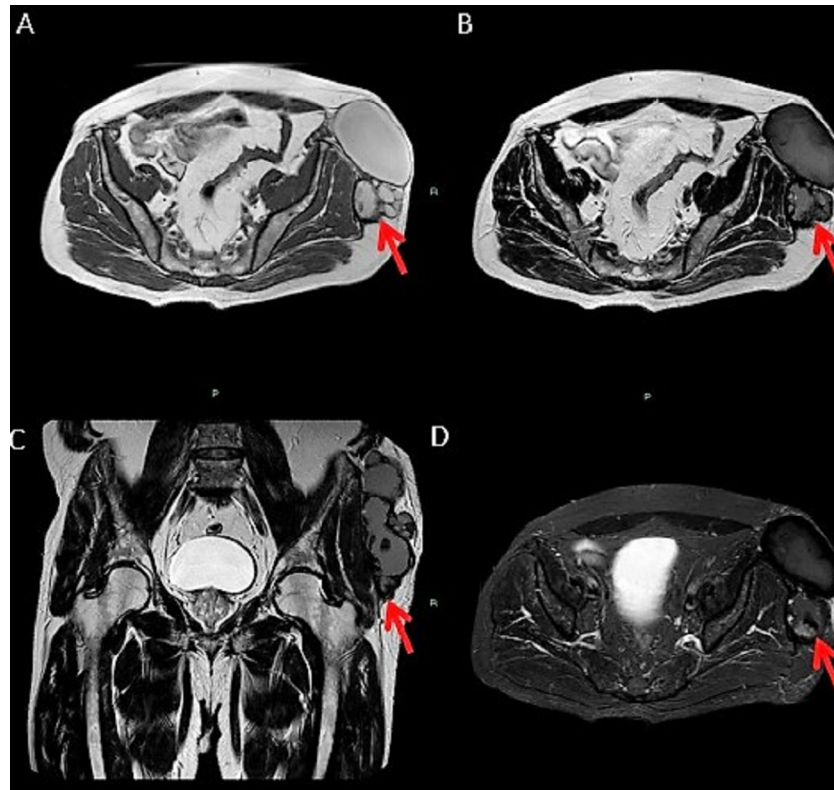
Axial and coronal MRI of the pelvis. Technique: 1.5-T MRI scanner, Sense Torso Coil. (A) TSE T1 sequence (axial plane): TR: 450 ms, TE: 8 ms, slice thickness: 7 mm, slice interval: 1 mm. (B) TSE T2 sequence (axial plane): TR: 3614 ms, TE: 120 ms, slice thickness: 7 mm, slice interval: 1 mm. (C) TSE T2 sequence (coronal plane): TR: 4096 ms, TE: 120 ms, slice thickness: 6 mm, slice interval: 1 mm. (D) TSE STIR (axial plane): TR: 4379 ms, TE: 50 ms, slice thickness: 7 mm, slice interval: 1 mm. The lesion shows a high signal intensity in T1-weighted sequences (A) and a low signal intensity in T2-weighted (B, C) and STIR (D) sequences. Inner components show an inhomogeneous signal intensity in all baseline sequences (arrows). MRI, magnetic resonance imaging; STIR, short tau inversion recovery; TE, echo time; TR, repetition time; TSE, turbo spin echo.
